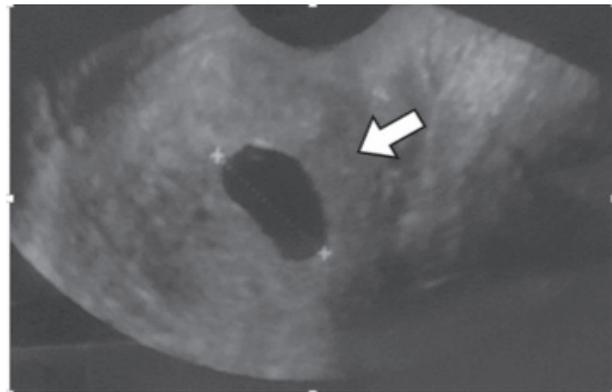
Transvaginal Ultrasonography Showing Gestational Sac in the Cervix and Ballooned Cervical Canal
